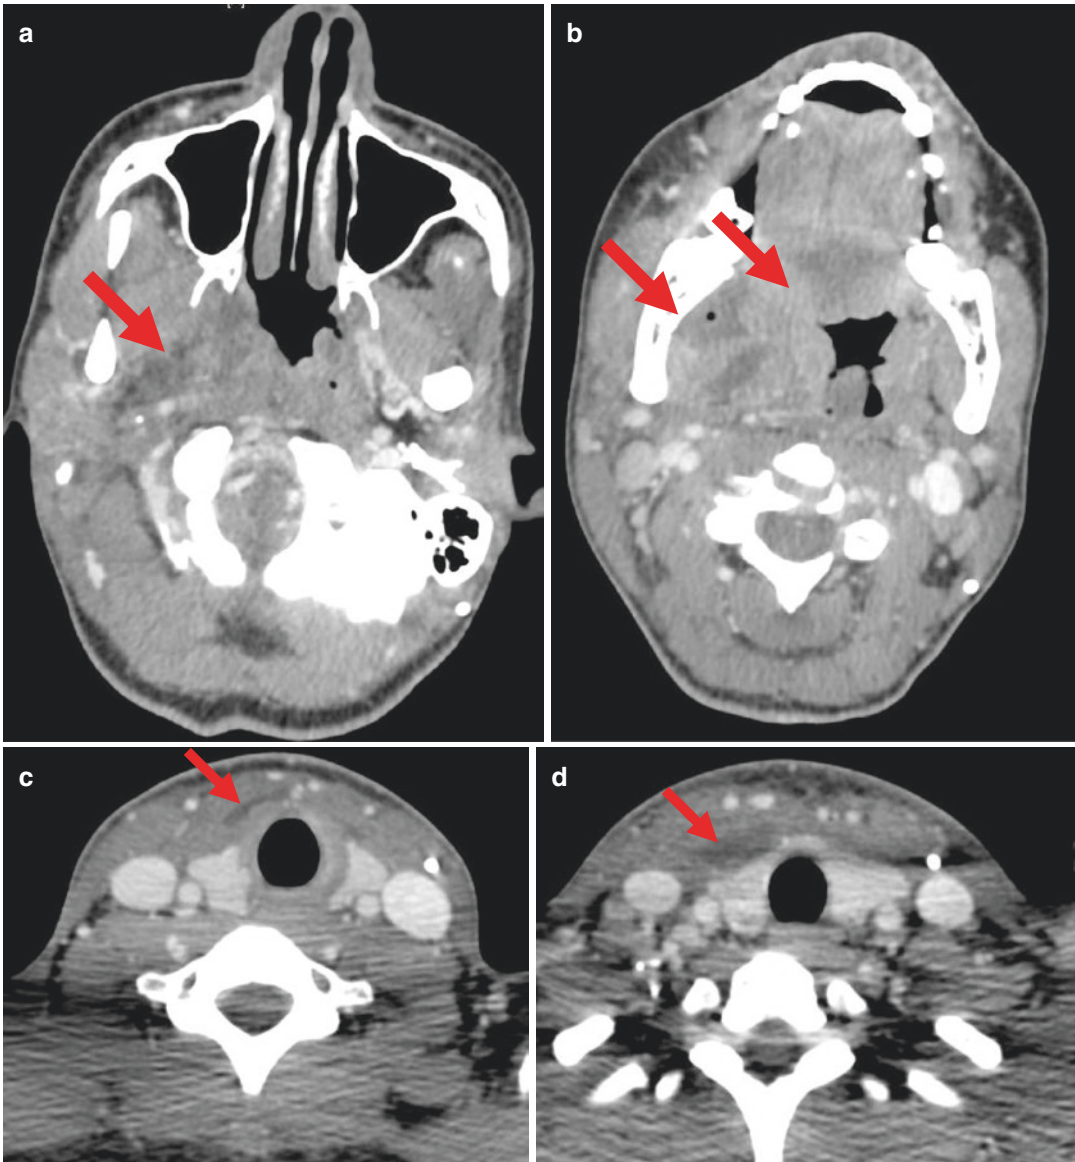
(a, b, c, d) 56 Y M with airway deviation and constriction due to parapharyngeal and retropharyngeal infection making intubation difficult. *Case 3*: 56 Y M presented to his PCP with right facial pain and swelling of 1 week duration. He was referred to the ED with chills, and a fever of 101.3. Clinical exam was notable for marked trismus to 1 cm, asymmetric swelling of right face and jaw with tenderness, cervical lymphadenopathy and a non palpable inferior border of the mandible. (a) Axial view of CT scan and (b) coronal view of CT scan showing
